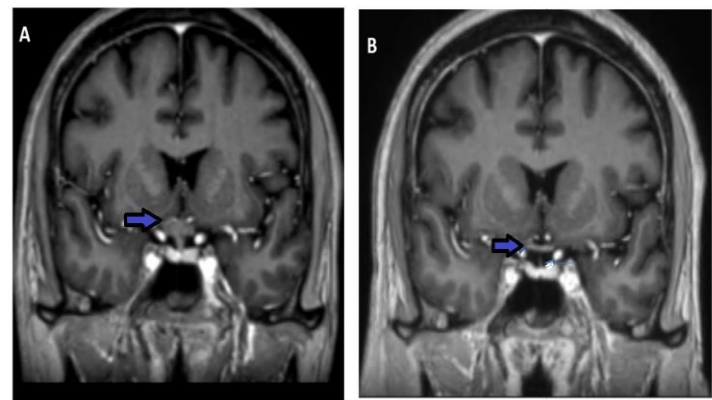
MRI Head. (a) Pre-treatment T-1 coronal postcontrast images Suprasellar solid tumour engulfing pituitary stalk and causing mass effect on optic chiasma. (b) Post-treatment T-1 coronal post-contrast images shows complete resolution of tumour with normal optic chiasma.
